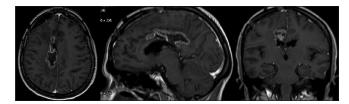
Magnetic resonance imaging with gad 14 months after the operation.
